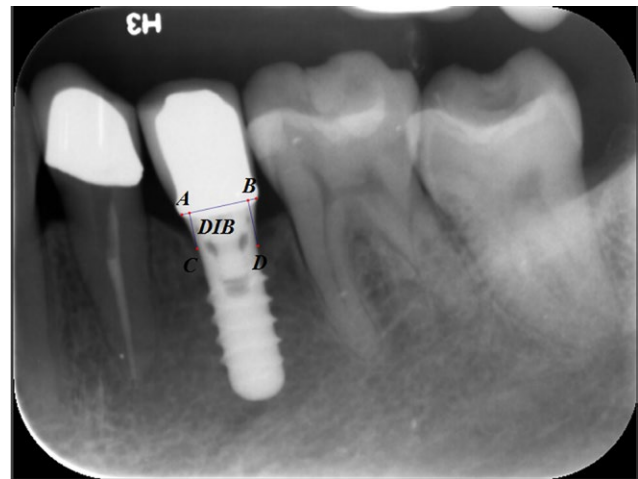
Landmarkers used for the radiographic measurements. A-B: the diameter of implant shoulder; C, D: the first bone-to-implant contact; DIB: the distance between the implant shoulder and the first bone-to-implant contact
